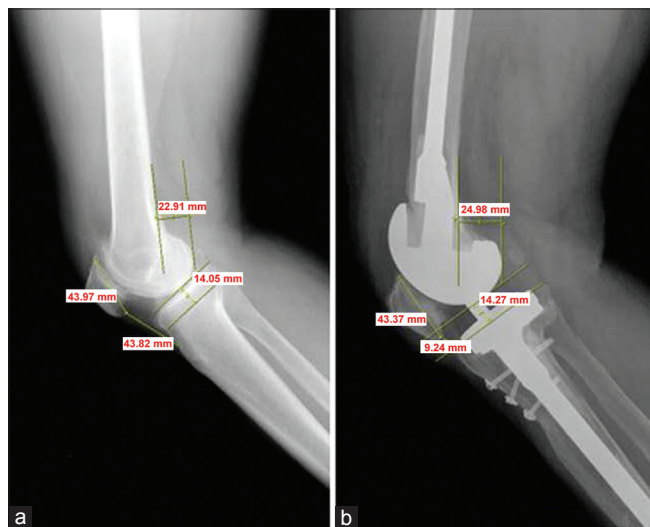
(a) Lateral radiographs of the knee before total knee arthroplasty. Joint line position is measured from fibular head to the lateral distal femoral condyle (Figgie's method) (b) lateral knee radiography postrevision. The Insall-Salvati ratio, joint line position, and patellar tendon length were measured
